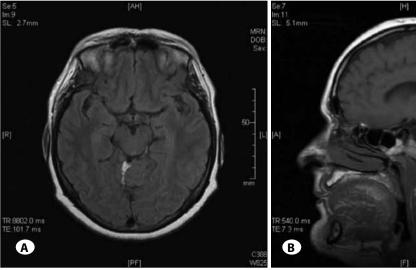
Curvilinear type lipoma located in the quadrigeminal cistern. A) axial T1-weighted MRI scan, B) sagittal T1-weighted MRI scan demonstrates hyperintense lipoma in the quadrigeminal and superior cerebellar cistern.
